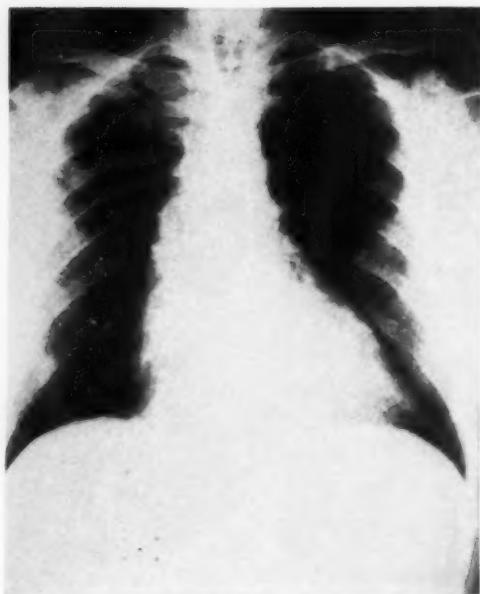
Routine admission postero-anterior chest roentgenogram of patient J. M. (case presentation) on Aug. 21, 1952, showing cardiac enlargement with a shadow of decreased density 2 cm. medial to the apparent left heart border.
